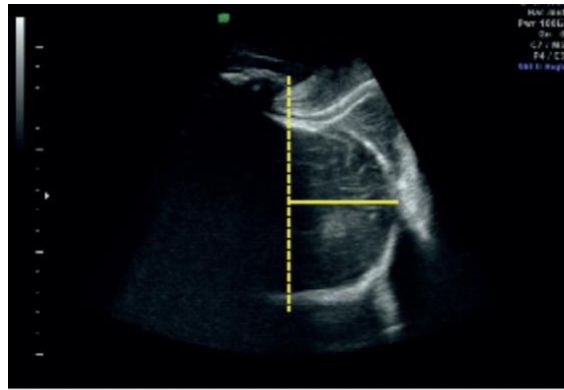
Sagittal transperineal ultrasound image showing head progression distance: solid line perpendicular to infrapubic line (Adapted from Y. Gilboa et al.)⁶⁰
